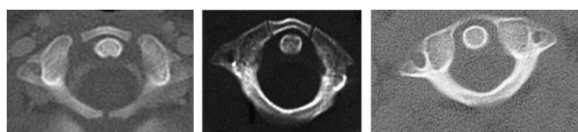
CT scan of C1 showing the presence of three (left), two (right), and no synchondrosis.
